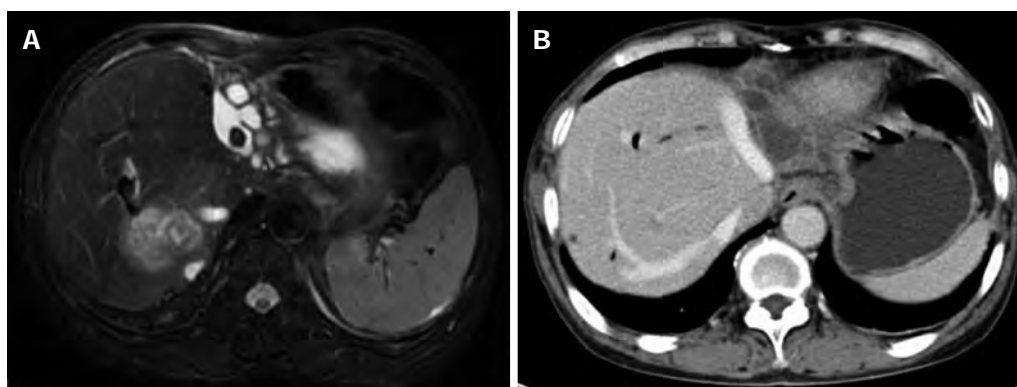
Preoperative imaging findings. A: Magnetic resonance imaging shows bilateral hepatolithiasis with infection at the posterior right lobe of the liver; B: Major hepatic vein on computed tomography.
